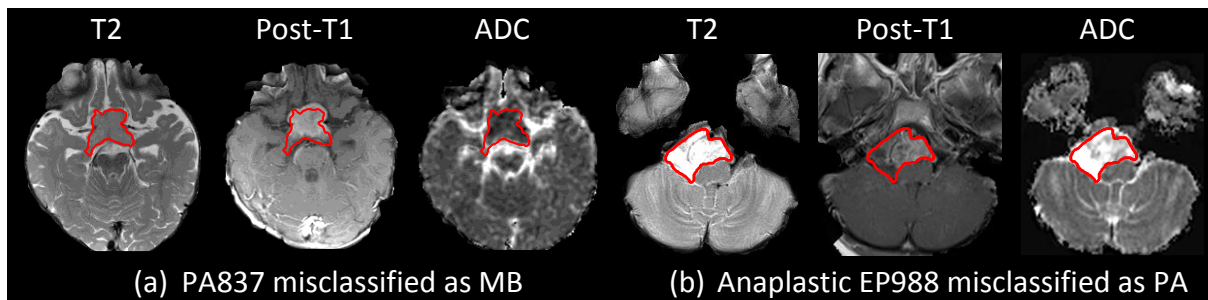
Two cases misclassified by ADC based TA but correctly predicted by the combined multimodal MRI based TA approach.
